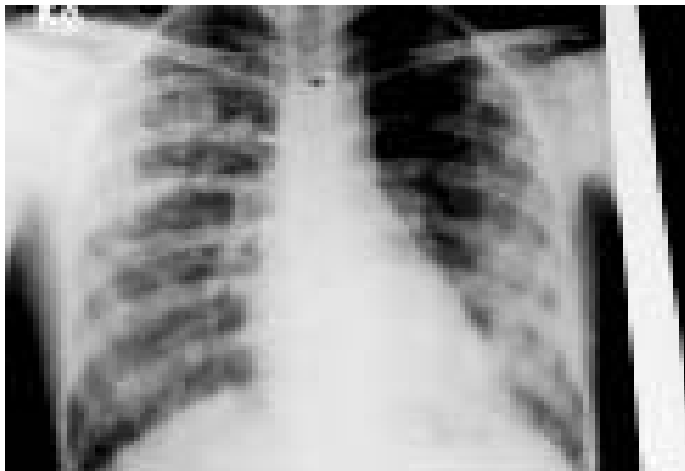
Xray chest showing metastatic deposits.
